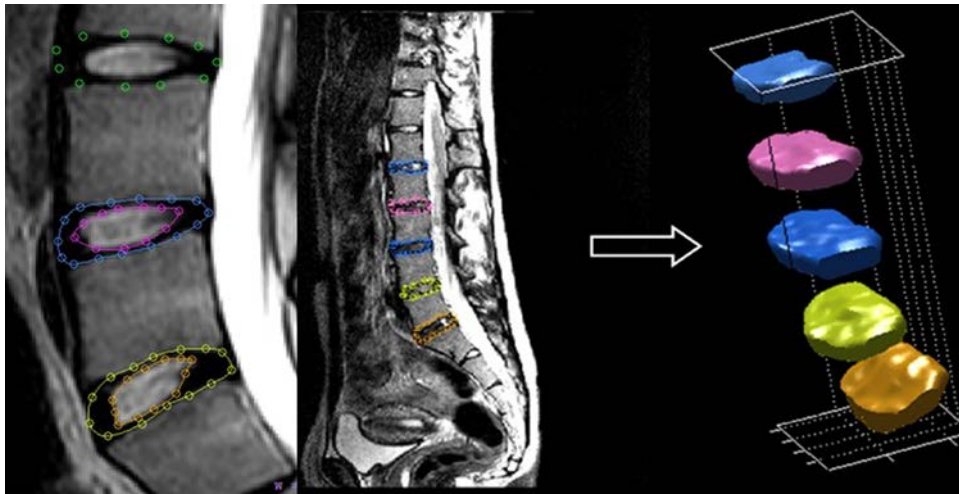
Semi-automated segmentation and automated volume reconstruction (Biomechlab®) of IVD from MRI slices (L5-S1 to L1-L2).
